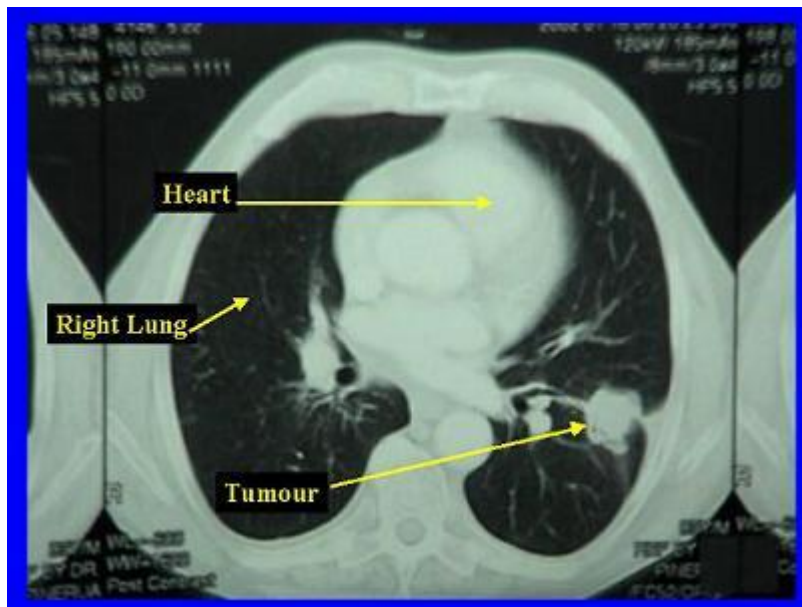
CT showing tumour in left lower lobe of lungs
